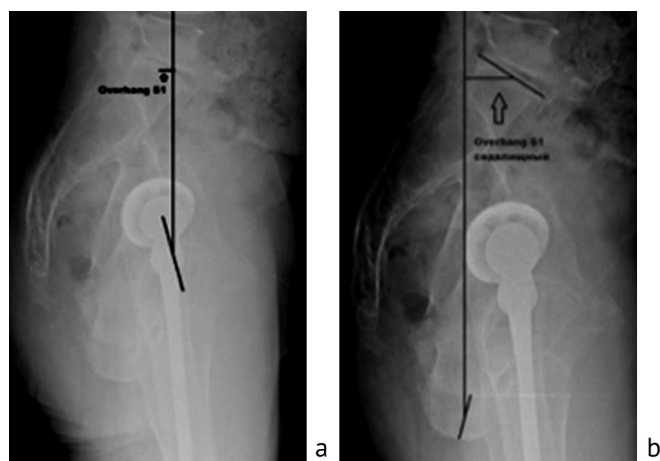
Lateral radiograph of the pelvis in sitting position: *a* finding the PI angle in sitting position; *b* finding the PI ischial angle in sitting position
